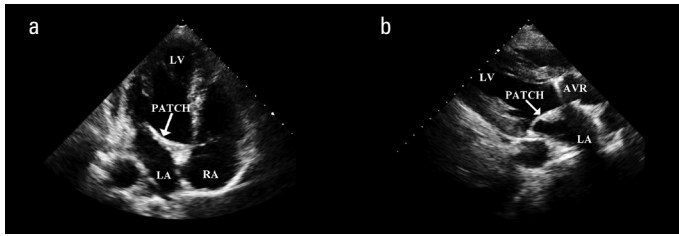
a, b. Transthoracic echocardiography after surgical repair. (a) Apical four-chamber view of patch. (b) Parasternal long-axis view of the prosthetic aortic valve and patch
